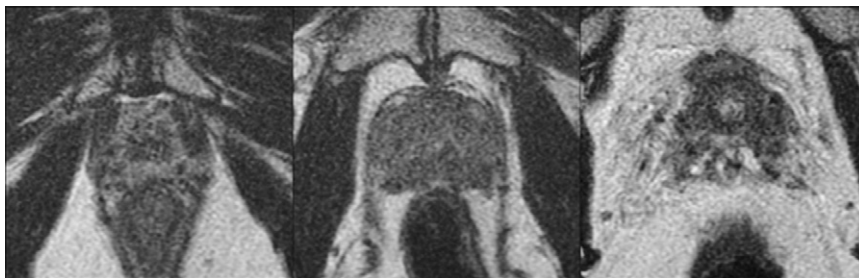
For unknown reasons, the magnetic resonance (MR) sequence parameters were adjusted for a series of patients such that the repetition time was shorter (3650 sec). Neither the prostate edge nor seed voids are well defined in the images displayed above. It was not understood why the imaging was so poor until these parameters were reviewed and corrected. Communication with the radiology department is critical to ensure a common understanding of the goals of MR imaging in the postimplant setting.
